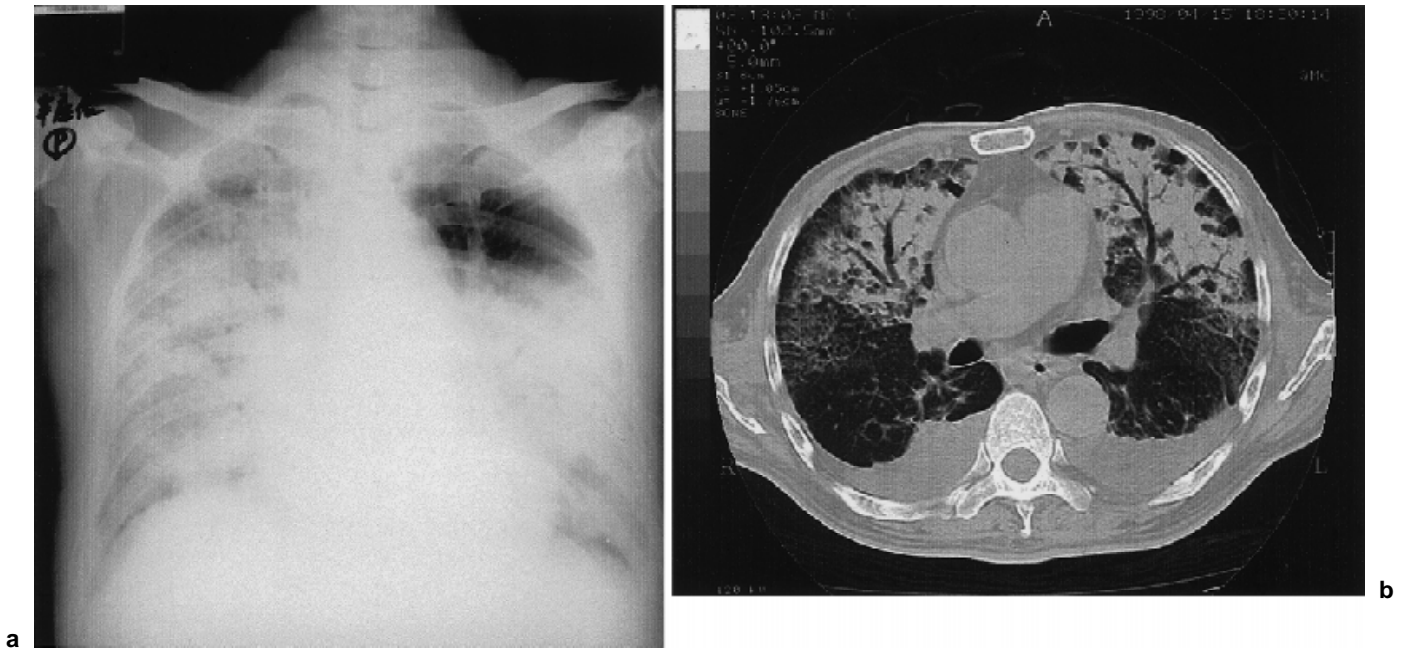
a Chest X-ray and b chest computed tomography scan showed infiltrative shadows bilaterally in the lungs
